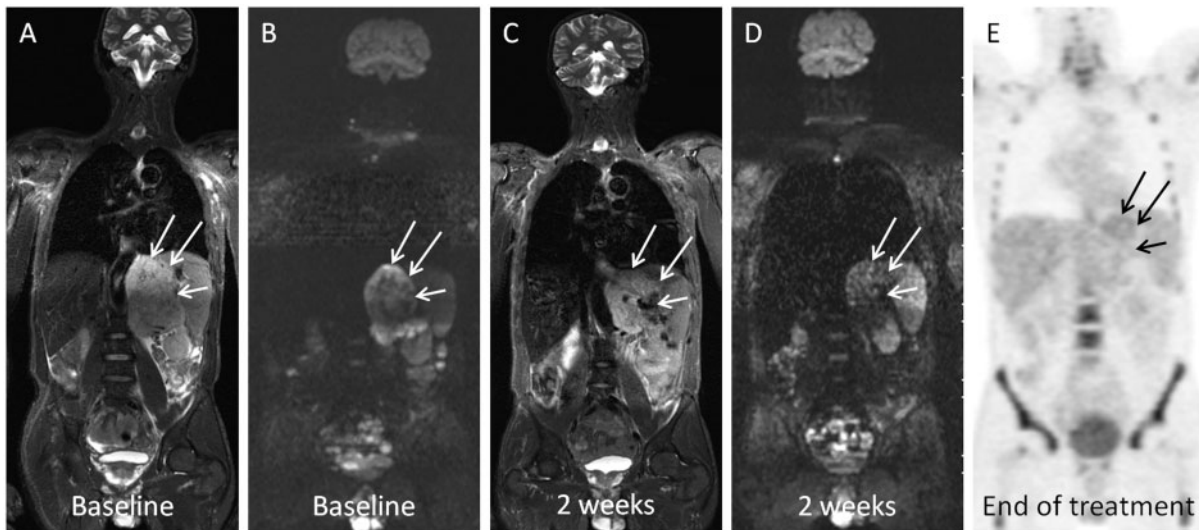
(A) Baseline coronal T2-weighted STIR and (B) MPR coronal reformatted WB DWI b1000 images show large NHL localization in the mesentery of the left upper abdomen (arrows). (C) Coronal T2-weighted STIR image shows limited decrease in size of the mass at 2 weeks after start of treatment. (D) MPR coronal reformatted WB DWI b1000 images show nearly complete regression of b1000 SI in the mass corresponding to an $ADC_{ratio_{2w}}$ above the threshold of 25%. (E) FDG-PET at the end of treatment shows complete metabolic response. The patient is disease free at 23 months of follow-up.
